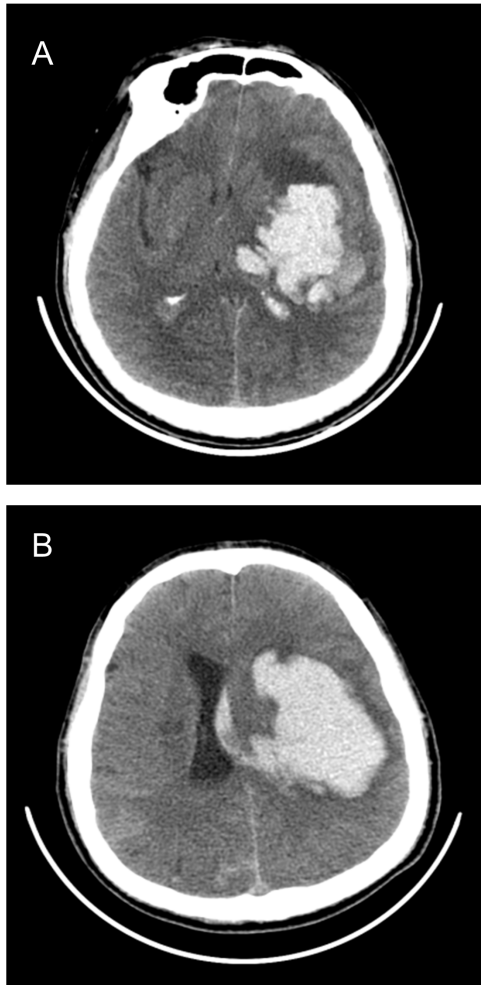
A CT scan showing a combined left basal ganglia hematoma (Figure 1, A) when the patient developed motor weakness in his right extremities during initial admission. A CT scan on second admission revealed a larger left basal ganglia hematoma (Figure 1, B).
